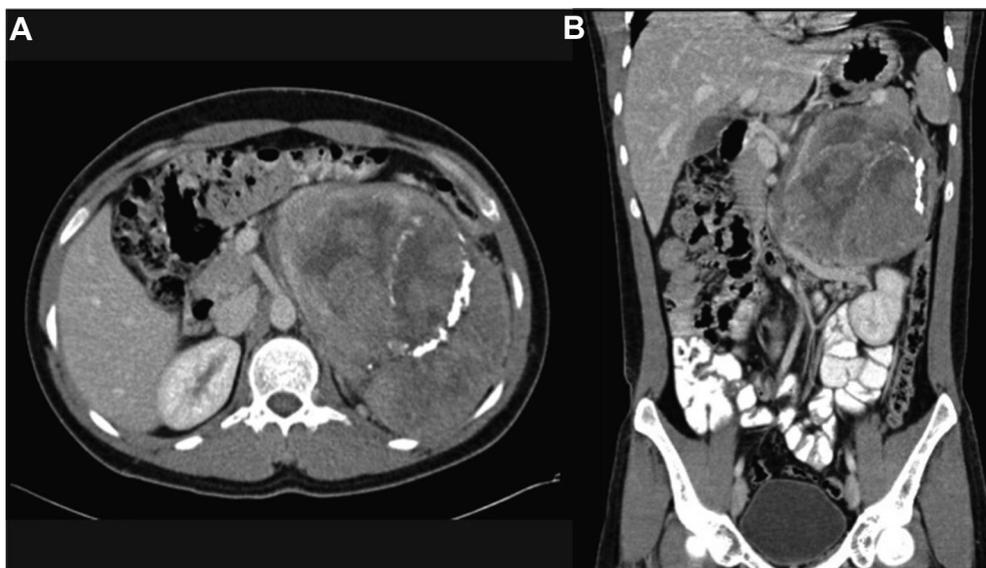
CT images of a patient with a large OAC of the left adrenal gland. (A) Axial and (B) coronal views demonstrating a large adrenal mass occupying left upper quadrant with heterogeneous enhancement, central necrosis, and areas of calcification. The mass seems to be intimately related with but not invading adjacent organs.
